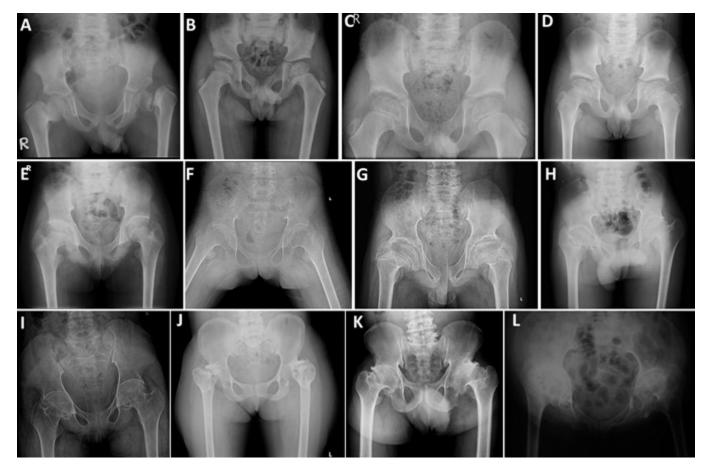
Pelvic radiographs demonstrating reduced hip joint spaces, large capital femoral epiphyses, short and broad femoral necks, and irregular acetabular roofs. Iliac crests are also irregular in adolescence.
